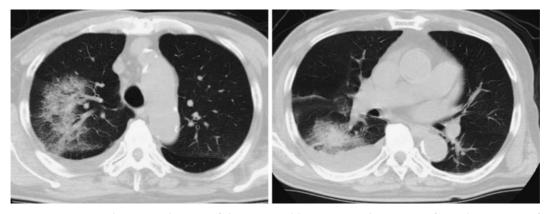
A computed tomography scan of the 86-year-old patient on admission confirms the presence of pneumonia.
